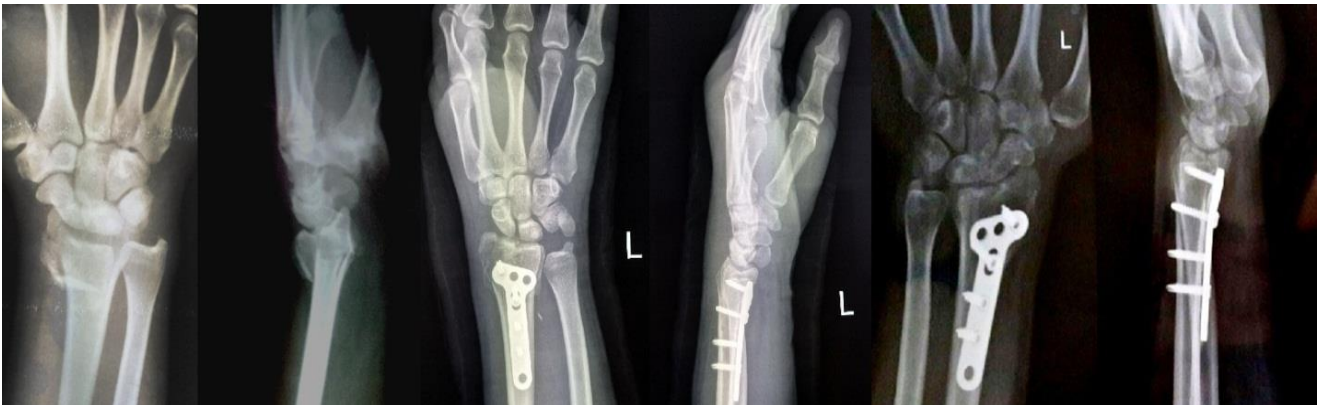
Pre OP, immediate post OP and 6 months post OP X-rays-volar plating.
